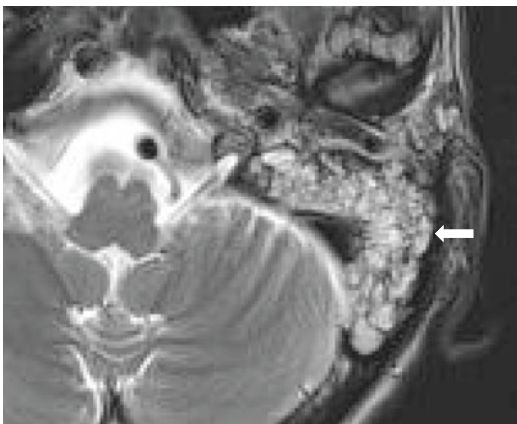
Axial T2 weighted MRI study showing a fluid signal effusion in the left mastoid and middle ear cleft (thick white arrow) with no overlying soft tissue swelling
